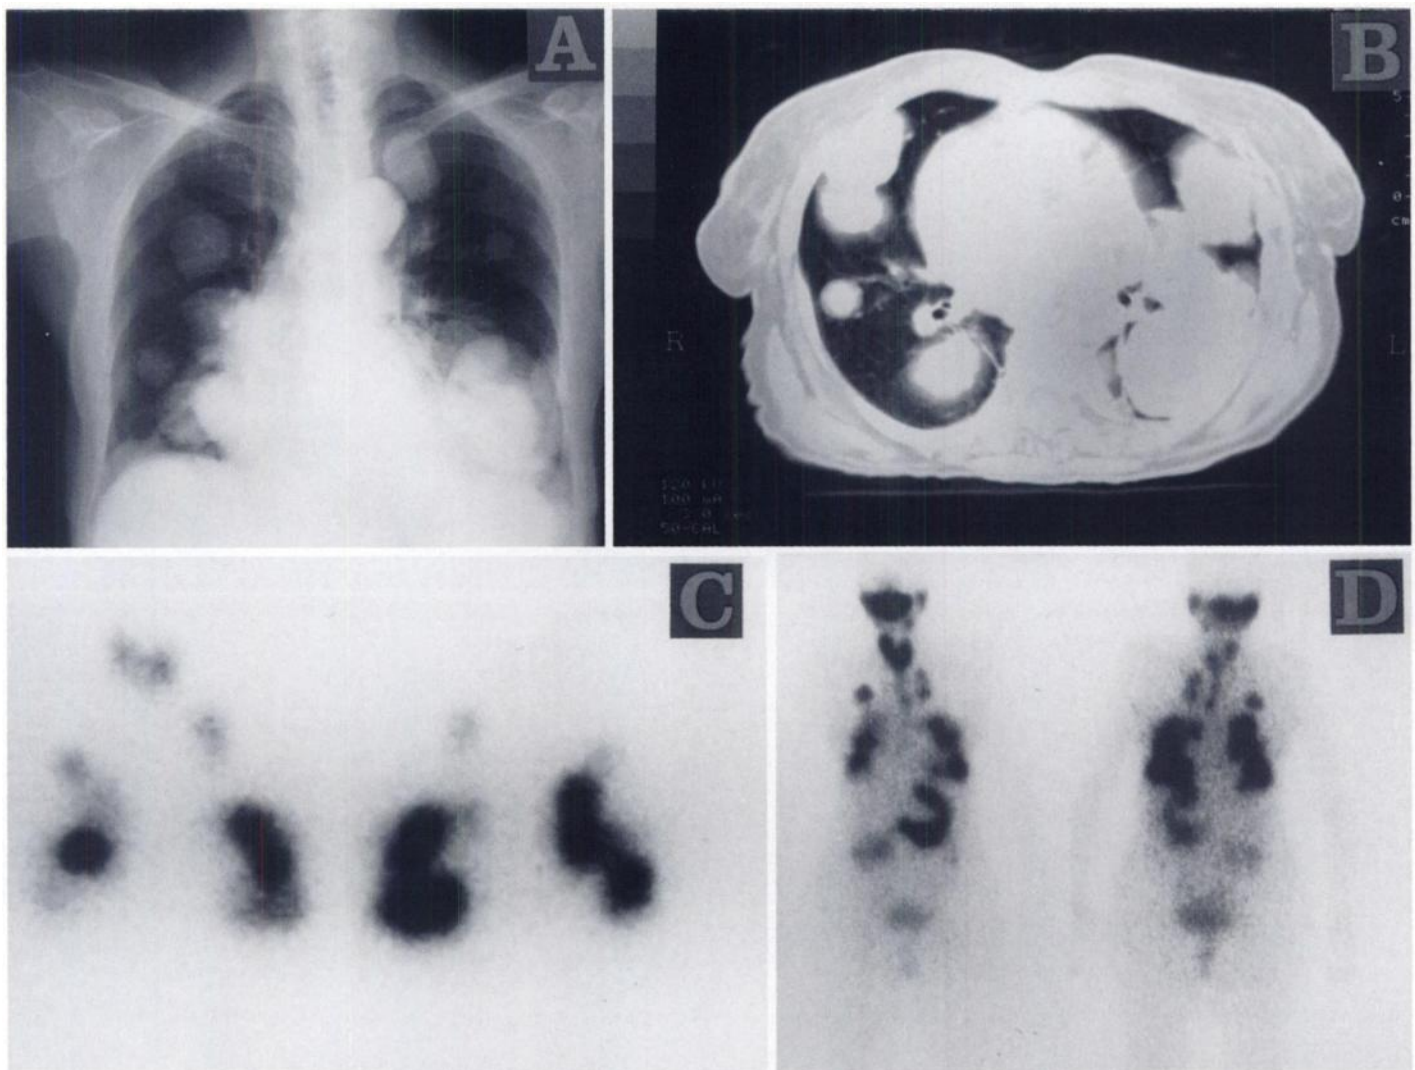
(A) Chest radiograph and (B) chest CT demonstrate numerous macronodular pulmonary metastases and associated findings of severe chronic obstructive pulmonary disease in both lungs. (C) Iodine-131 scintigraphy of neck and chest in anterior and posterior projections shows residual thyroid tissue and intense, bilateral, focal pulmonary accumulation of radioiodine. (D) Technetium-99m-pertechnetate whole-body scan in anterior and posterior projections also demonstrates trapping of pertechnetate in residual thyroid tissue and in pulmonary lesions.
